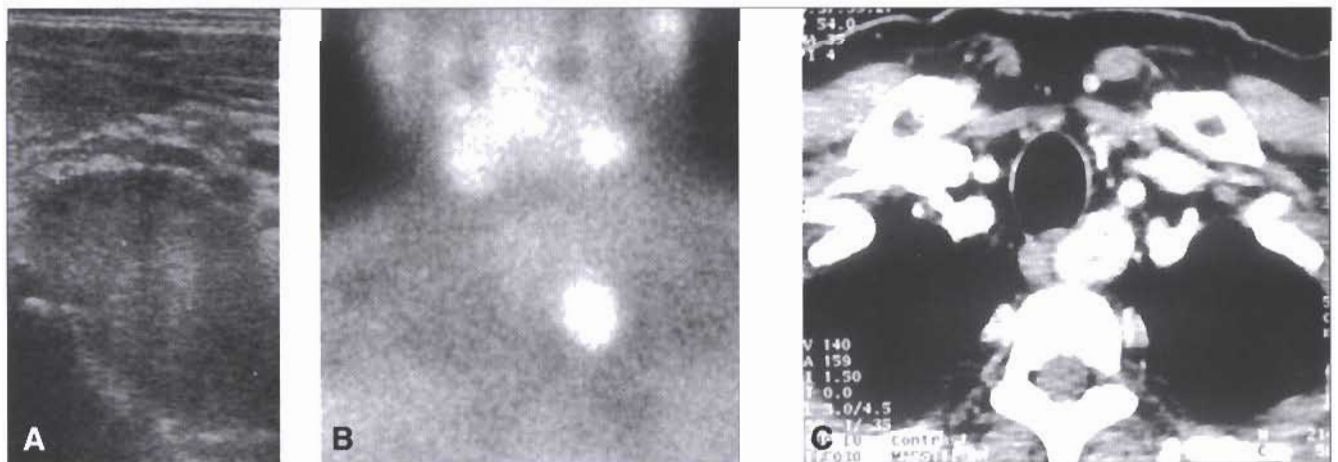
Patient 2: parathyroid adenoma. A) Ultrasound: at the infrajugular left parasagittal site a scarcely echoic mass, with sharp edges is present. B) ⁹⁹Tc-MIBI Scintigraphy: image obtained 90 min. after injection of the tracer; a "hot" spot is shown in the left upper mediastinum-low neck. C) Computed tomography: a strongly contrast-enhanced spherical mass was visible in the left side of the esophagus between the trachea and a vertebral body.
